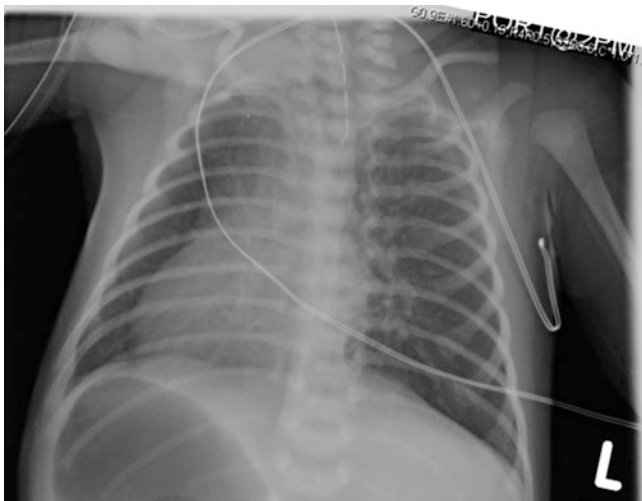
EA/TEF with situs inversus. Chest radiograph of a neonate with EA/TEF. The multi-orifice orogastric tube (with side orifices) ends at T3–T4 reflecting EA. The cardiac silhouette and gastric bubble are reversed, present on the right side. Echocardiogram verified the presence of a ventricular septal defect. The large gastric air bubble is consistent with a distal tracheoesophageal fistula
